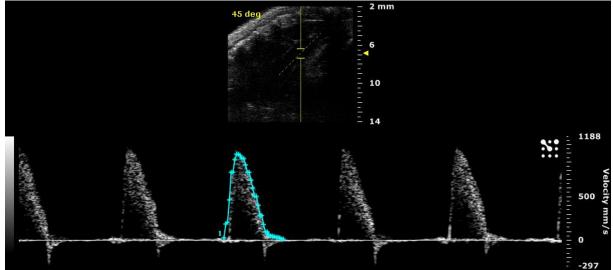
PW Doppler Mode waveform of the aortic valve outflow from a suprasternal view, showing a VTI trace.
